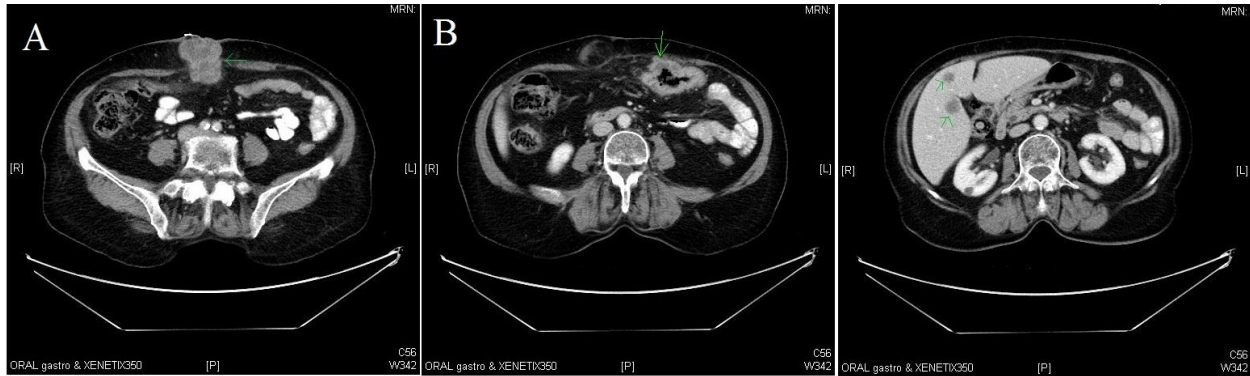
Computed tomography (axial images) of abdomen showing (A) a mass of 4.9 x 5.2 cm size within umbilicus and adjacent; rectus abdominis muscle, (B) asymmetrical mass in transverse colon of size 8 cm and (C) hepatic metastasis in II, IV and VIII segm.
